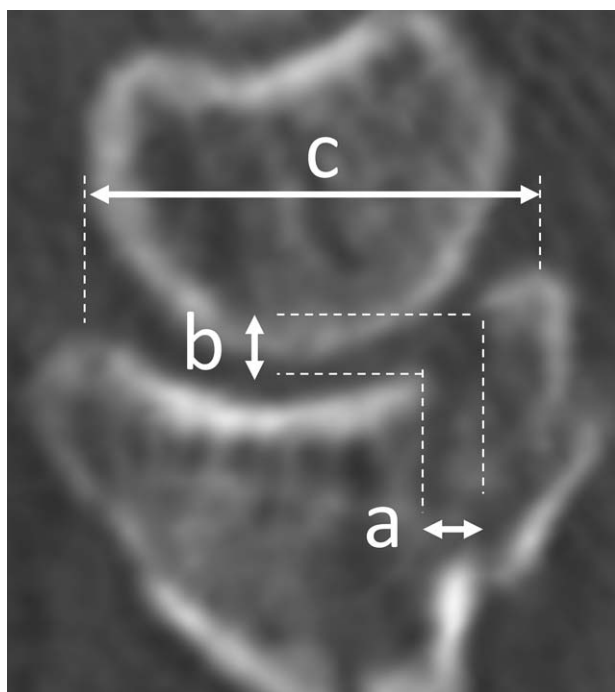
Sagittal-view CT taken for the measurement of articular gap distance (A) and step-off (B). Since evaluating articular gap accurately at 6 months after surgery is difficult due to the effect of osteogenesis, we evaluated changes in articular width (C) instead of measuring gap distance. Gap distance was measured preoperatively and immediately postoperatively. Step-off and articular width were measured preoperatively, immediately postoperatively, and at 6 months postoperatively. CT=computed tomography.
